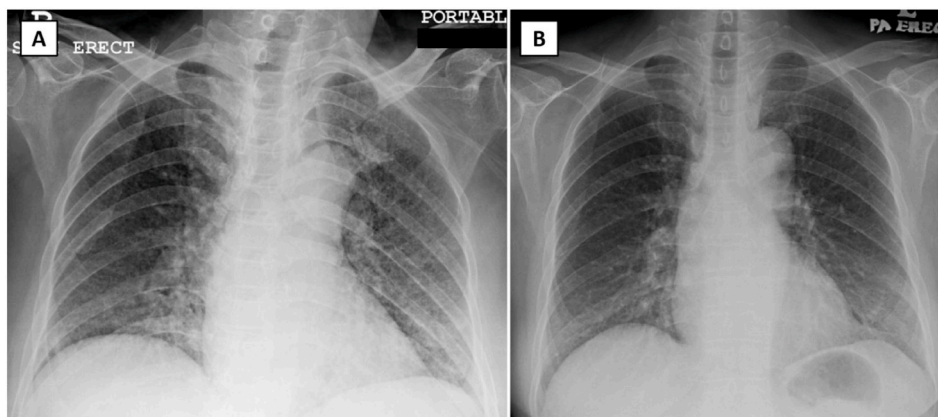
Chest radiograph of patient 1 on admission demonstrates nodular and air space opacities bilaterally (Panel A). These opacities significantly resolve on day 12 of admission (Panel B). No cavity, enlarged hilar node, or pleural effusion is seen in both chest radiographs.
